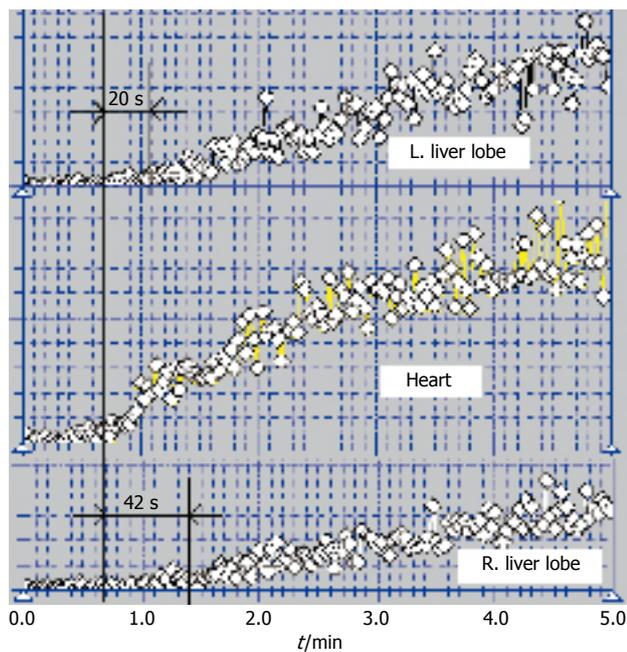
Per-rectal portal scintigraphy dynamic curves. Separate analyses of the two liver lobes for a cirrhotic patient (stage 4b).
